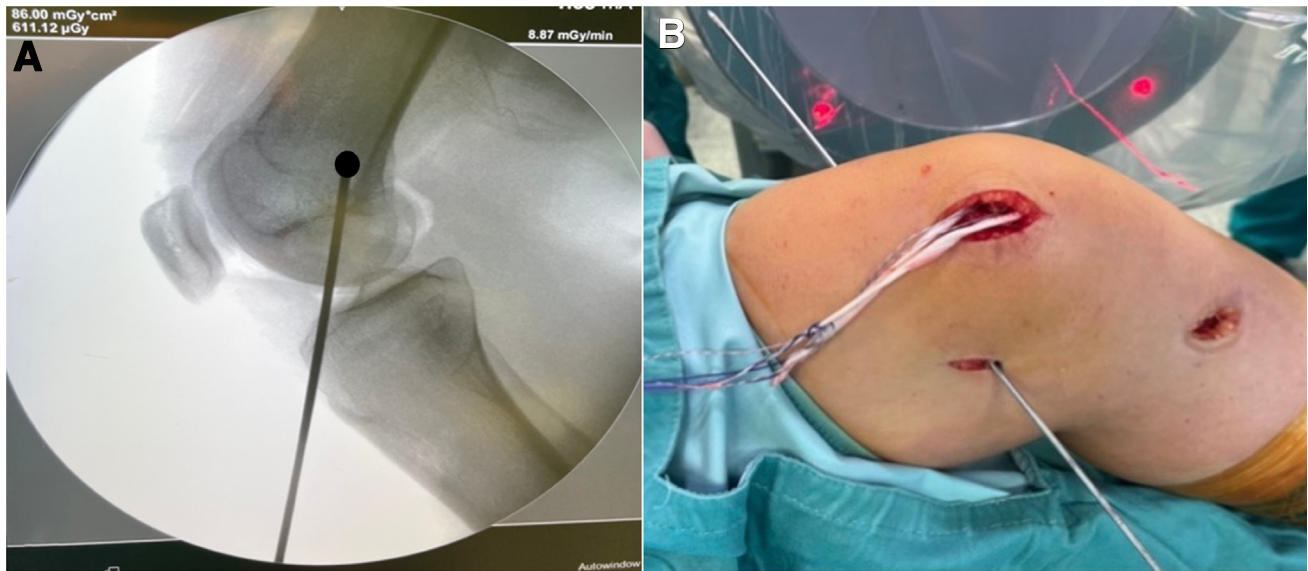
Medial view, knee flexed approximately to 90°. (A) The Schöttle point (circle) is identified on a lateral radiograph. Radiographically, originates slightly anterior to the posterior femoral cortex reference line and immediately posterior to the most posterior aspect of the Blumensaat line. (B) The closed eyelet K-wire is shuttled medial to lateral transversely to the distal femur.
